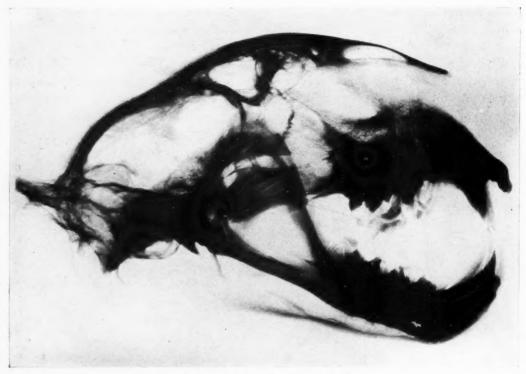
Radiograph of skull of mountain lion.
